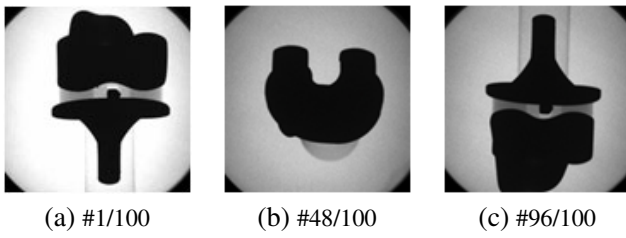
X-ray images of TKA implants.
